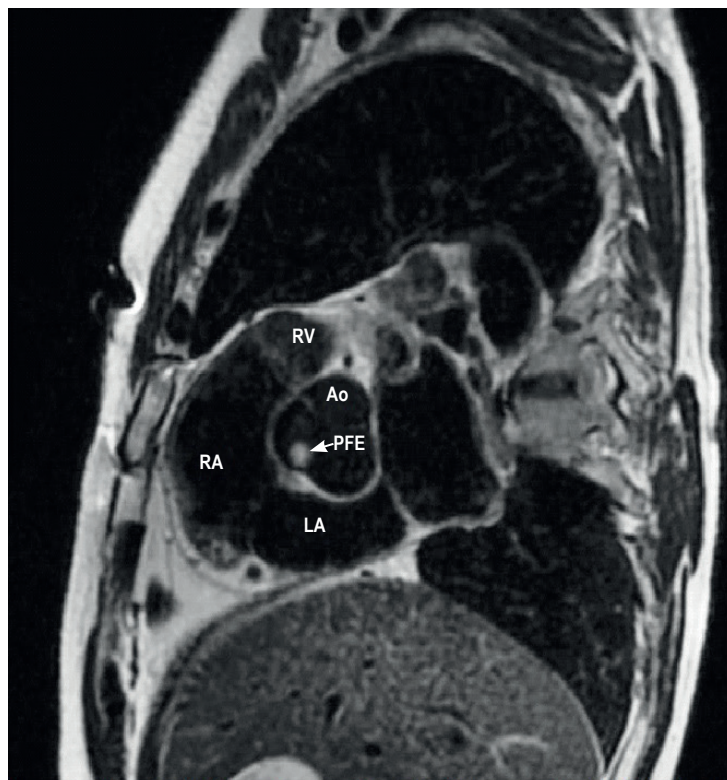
Magnetic resonance imaging. LA: left atrium; RA: right atrium; RV: right ventricle; Ao: aorta; PFE: papillary fibroelastoma.
